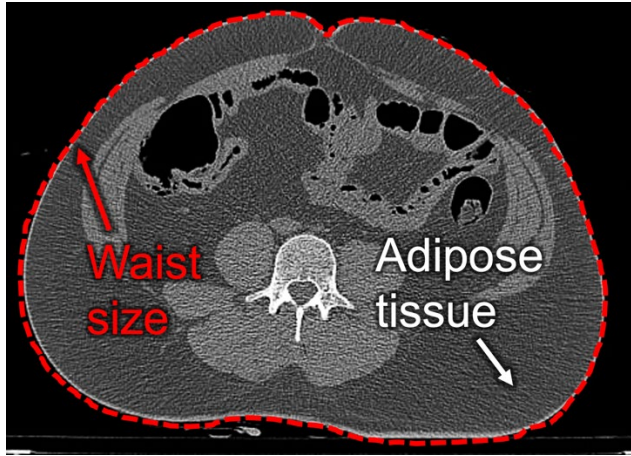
Measurement of waist size from a CT image.
